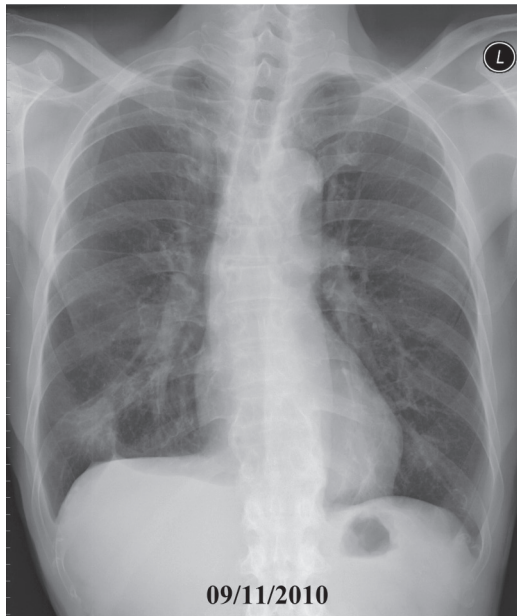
The chest x-ray shows almost clear infiltration and right pleural effusion.
